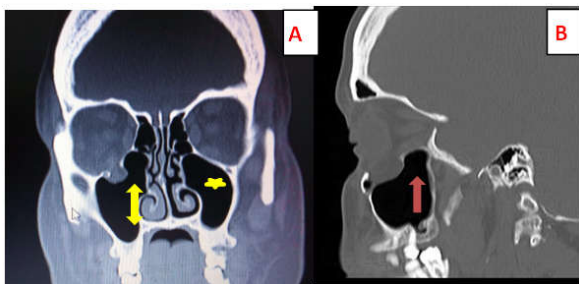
A, Coronal CT showing right blowout fracture with herniation of the orbital fat to sinus (arrow), clear sinus with thin uniform lining (star) and enlarged turbinate obstructing osteum (double arrow). B, Parasagittal CT showing floor disruption with tissue herniation to sinus (red arrow)
